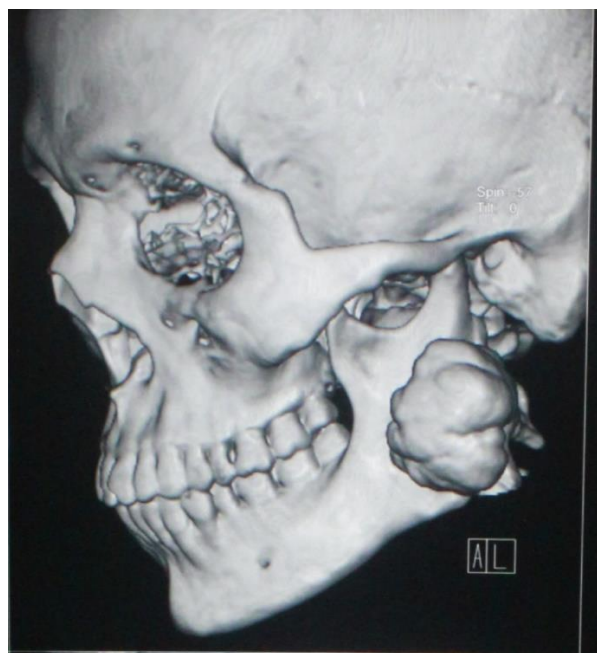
CT Scan shows the swelling at angle of mandible on the left side.
